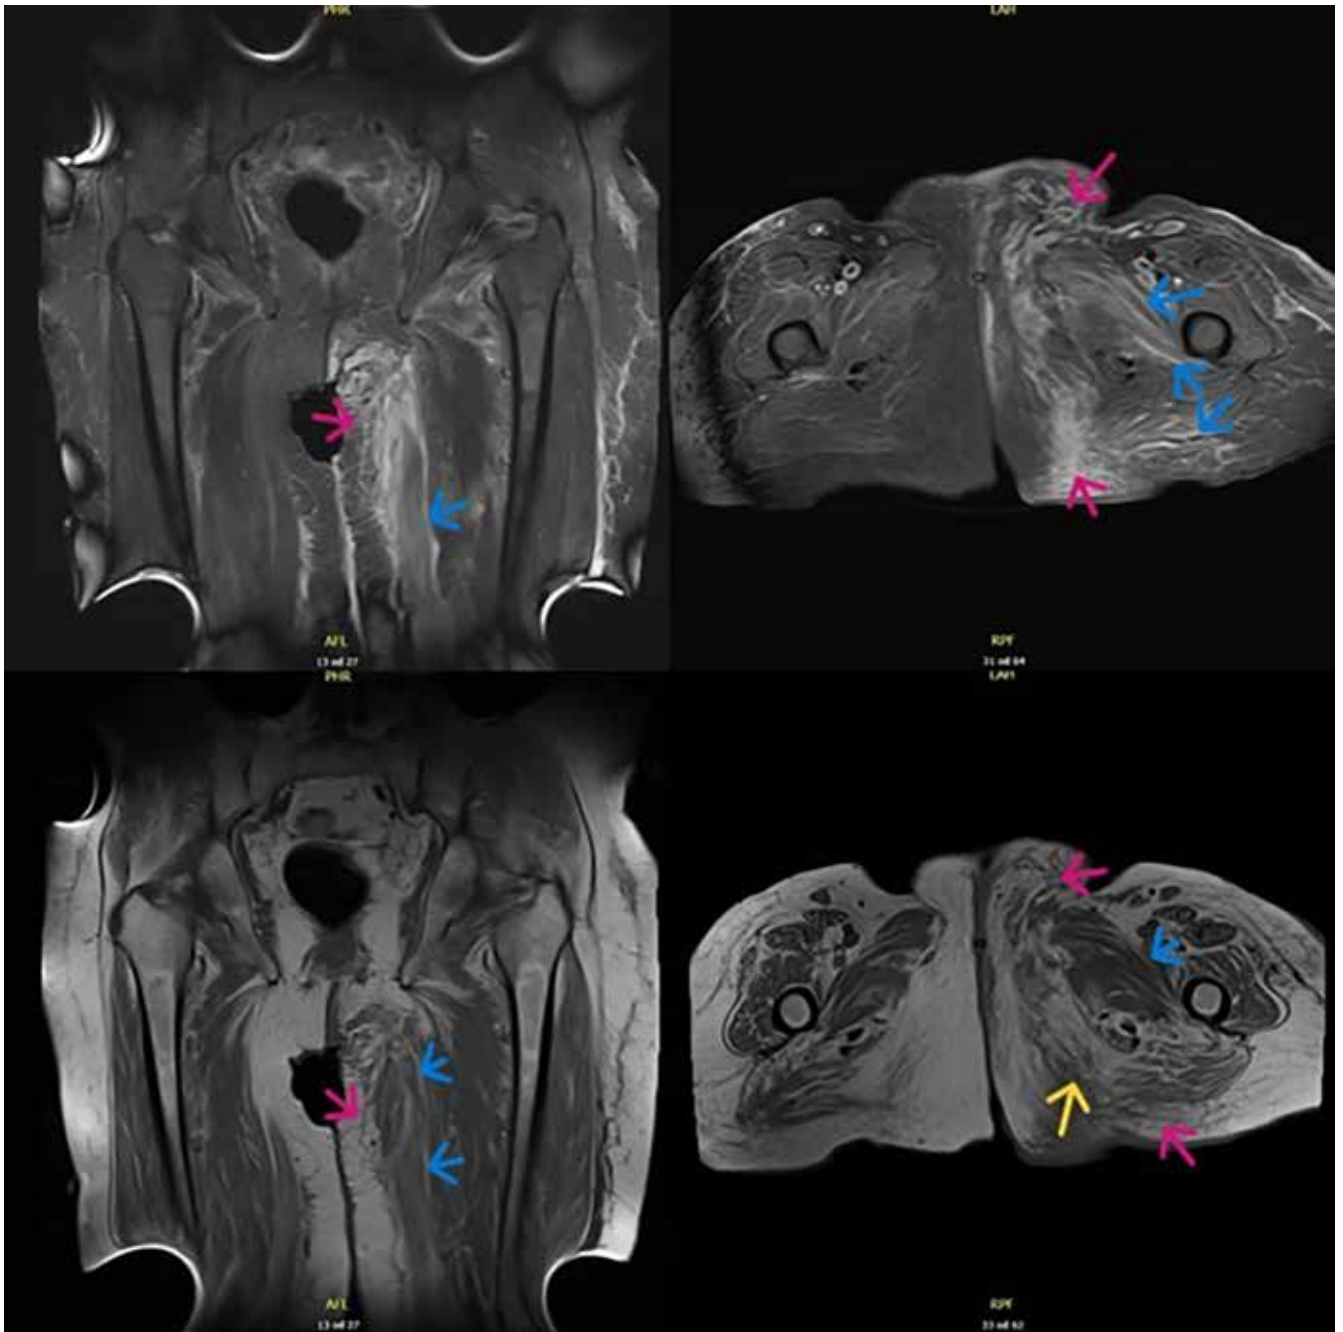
MRI of the pelvis shows cellulitis on the inner and dorsal aspects of the left thigh (pink arrows) and fluid collection in the labia on the left, lateral to the left gracilis muscle (yellow arrows). Additionally the MRI shows mild-to-moderate thickening of the superficial and deeper fascia (blue arrows).
